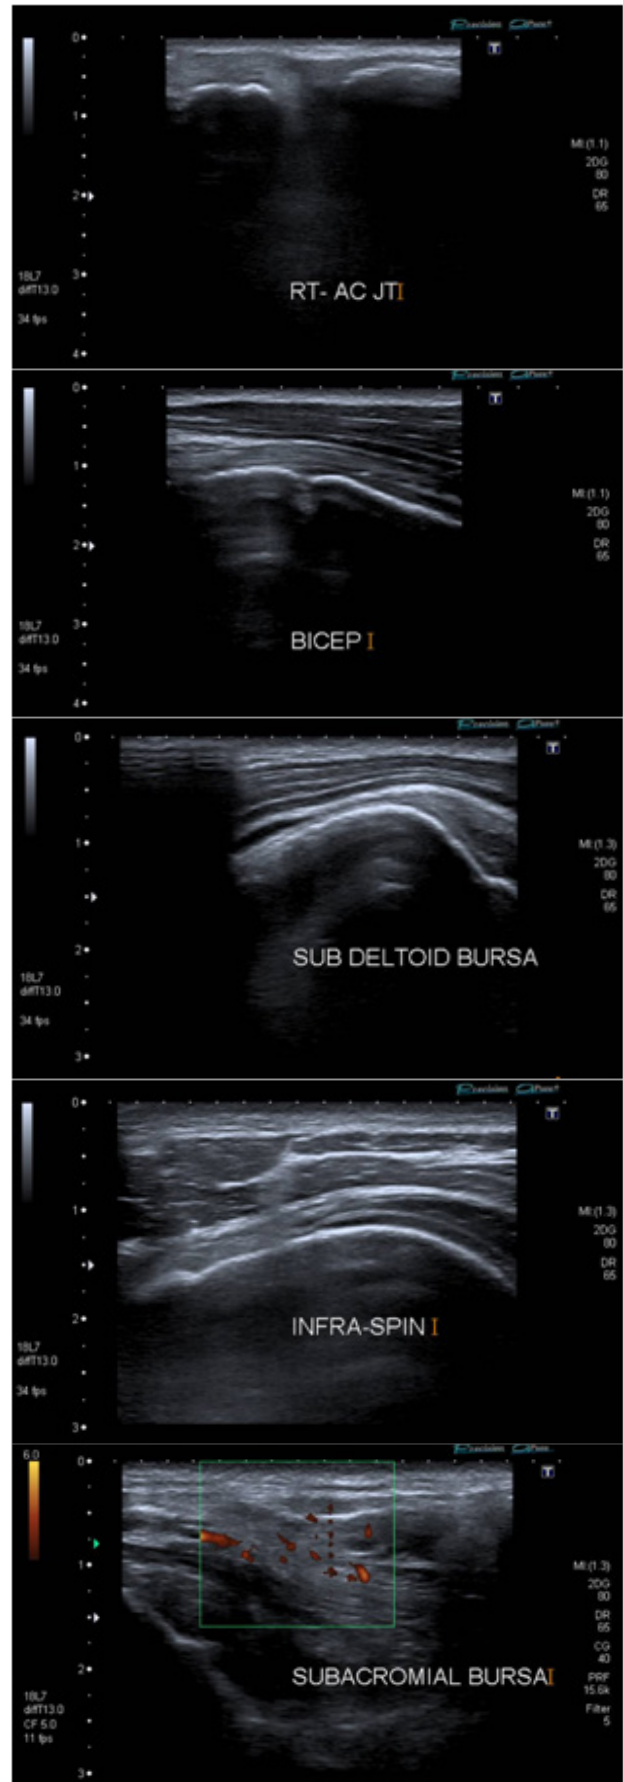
Ultrasound images of right AC joint, biceps, subdeltoid bursa, infraspinatus, subacromial bursa.
